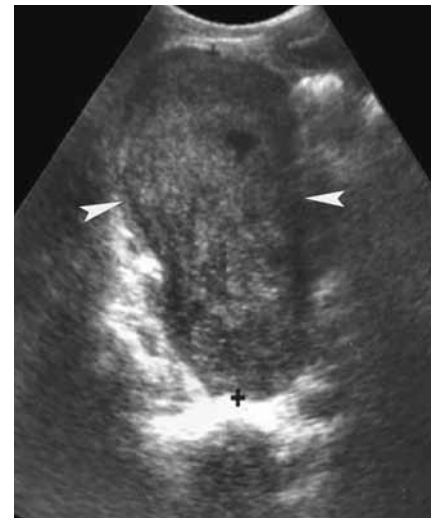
Ultrasound of the abdomen showing a large pelvic mass, predominantly solid with a few small hypoechoic areas (arrows).
